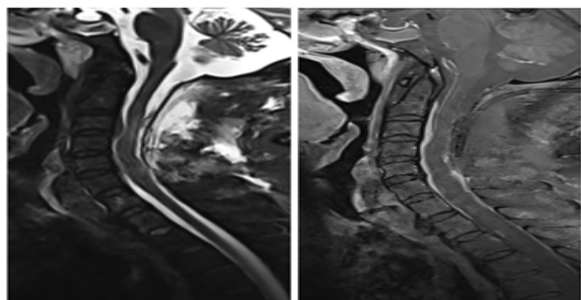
Post-operative MRI images showing small anterior residual lesion with no cord compression.
